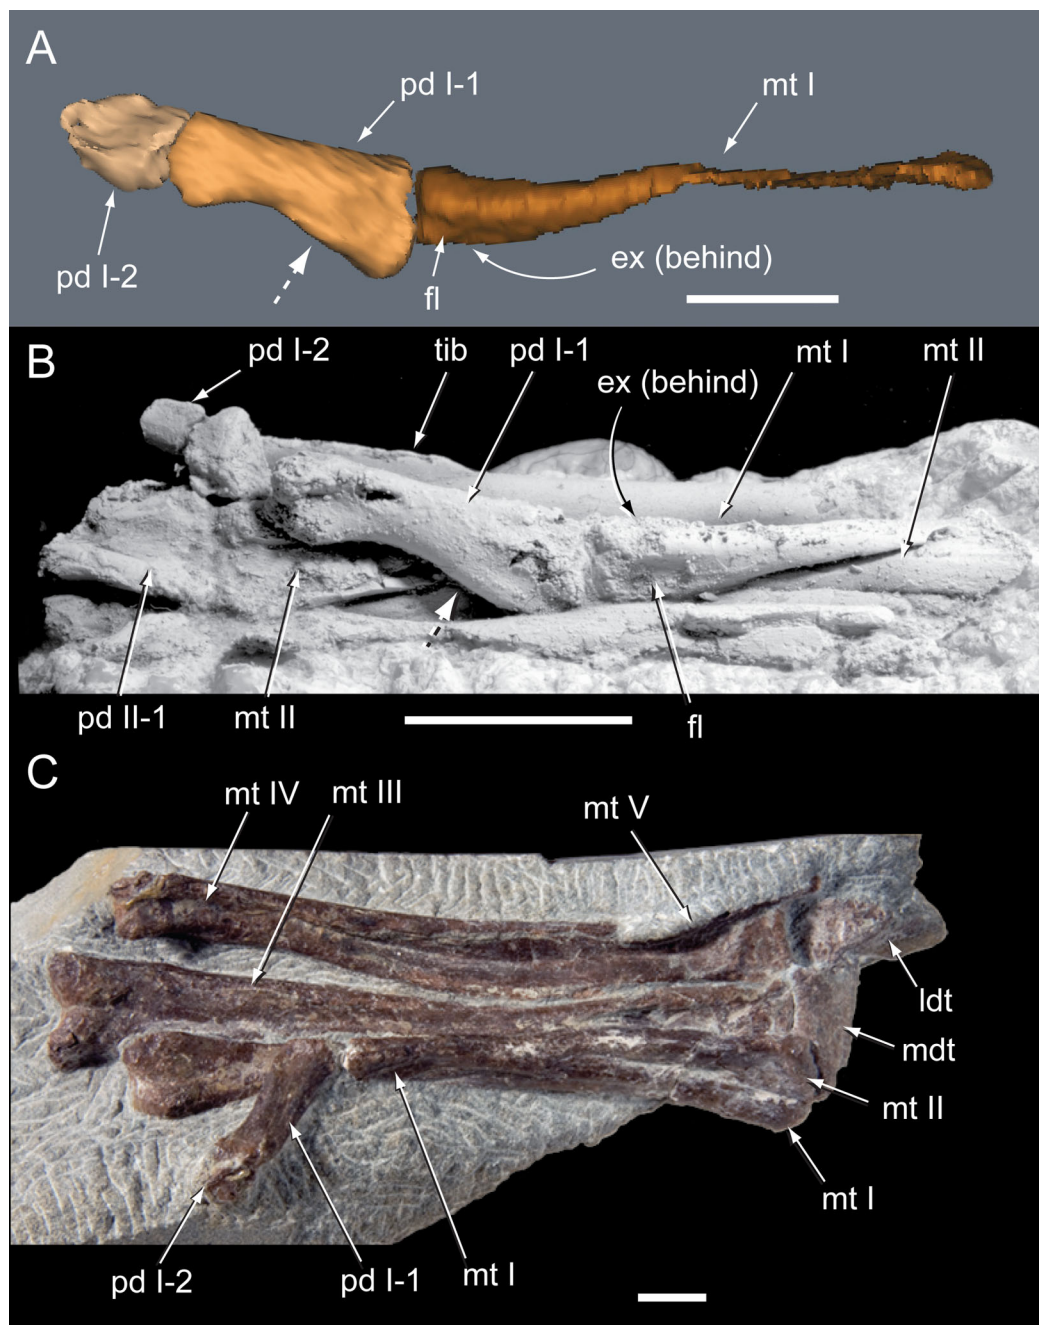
Pedes of selected Eumeralla Formation ornithopods in plantar view. (A) CT model of right pedal digit I of the *Diluvicursor pickeringi* gen. et sp. nov. holotype (NMV P221080). (B) Right partial pes of NMV P185992/NMV P185993, NH₄Cl coated. (C) Left partial pes of NMV P186047. Dashed arrows in A and B indicate lateral flaring on the cotyle. Abbreviations: ex, extensor groove; fl, flexor groove; mdt, medial distal tarsal; mt #, metatarsal position; pd #, pedal digit number and phalanx position; tib, tibia. Scale bars equal 10 mm. [Full-size !\[\]\(5fd6ef84f97f42d7f8b34275f1b65312_img.jpg\) DOI: 10.7717/peerj.4113/fig-31](https://doi.org/10.7717/peerj.4113/fig-31)
